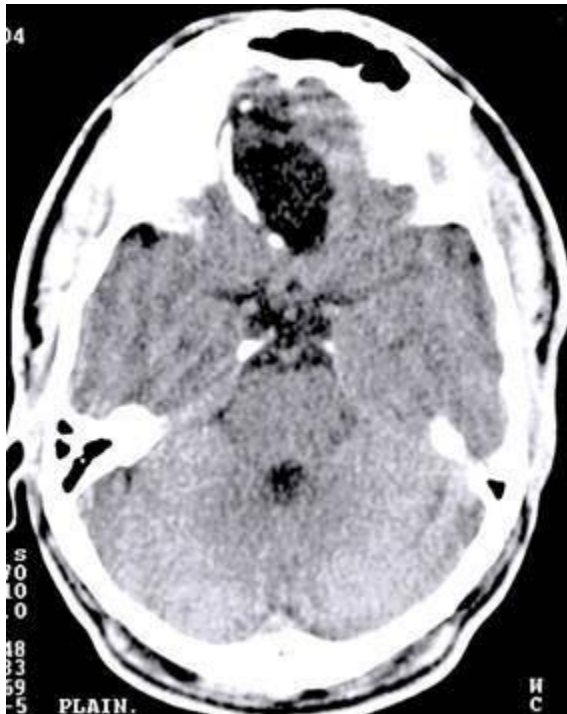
Unenhanced CT scan brain (axial section) of patient 2, showing a hypodense mass lesion in the fronto-basal location, mainly on the right side. Right lateral wall of cyst is lined with calcifications.
